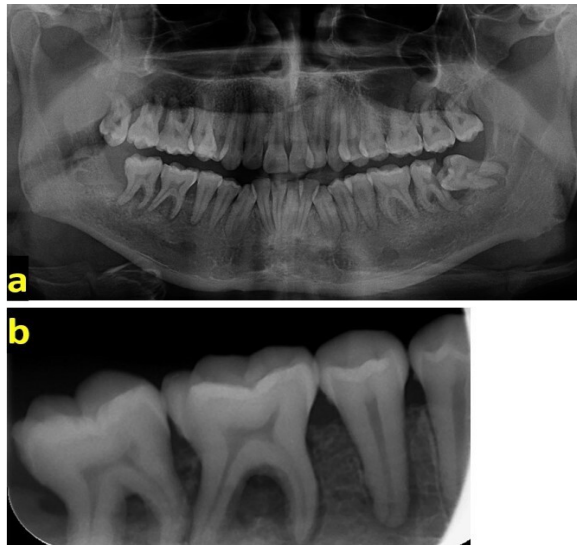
Panoramic (a), and periapical radiographic image of right mandibular posterior teeth (b). Osteolytic lesions, peri-radicular and periapical radiolucencies of the posterior teeth of both jaws. Note the irregular periodontal space widening and loss of lamina dura on the periapical image.
